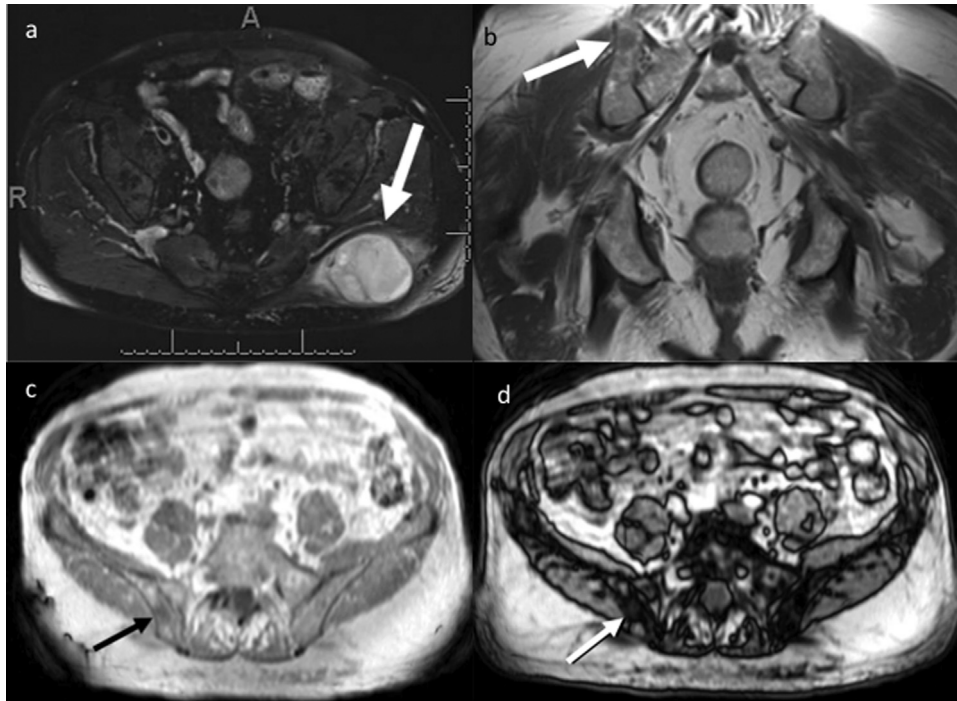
a–d: 3a: Axial T2-weighted FSE with fat suppression showing large soft tissue mass; TR: 4551 ms, TE: 67 ms. 3b: Coronal T1-weighted SE of pelvic metastasis; TR: 684 ms, TE: 12ms. 3c: Axial in-phase GRE; TR: 213 ms, TE: 4.6 ms, flip angle: 80°. 3d: Axial opposed phase GRE; TR: 206 ms, TE: 2.3 ms, flip angle: 70°.
